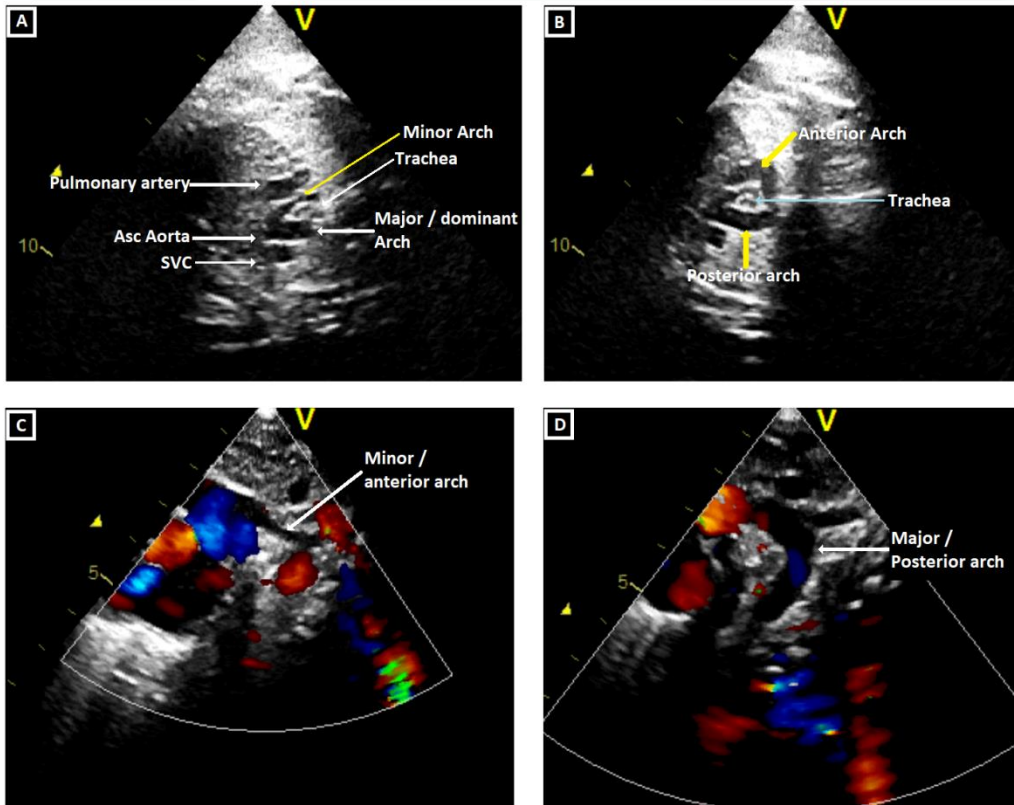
Prenatal Fetal echocardiographic examination shows the dominant arch extending from the aorta to the right trachea, and separated from the ascending aorta and aberrantly following the tracheal left anterior (A). In the posterior tilt of the probe, it is seen that both arches combine in the posterior to form the arch of the pattern and surround the trachea in a ring-shaped manner (B). In the postnatal echocardiographic examination, a minor arch (3,4mm) (C) and a well-developed dominant arch is seen in the suprasternal section (D).
